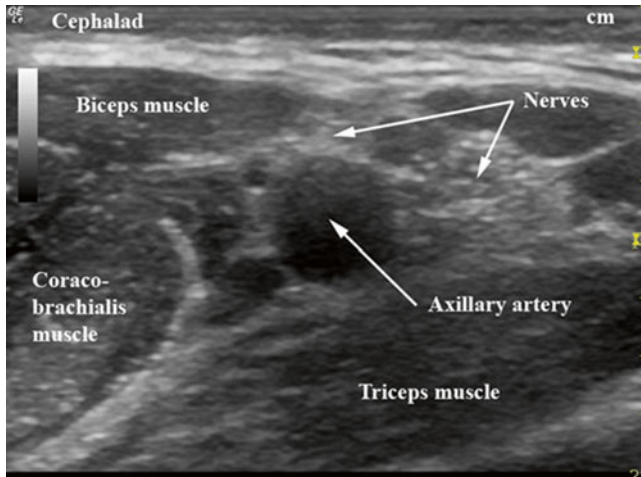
Ultrasound view of the brachial plexus in the axilla (With permission from Buckenmaier and Bleckner [71])
